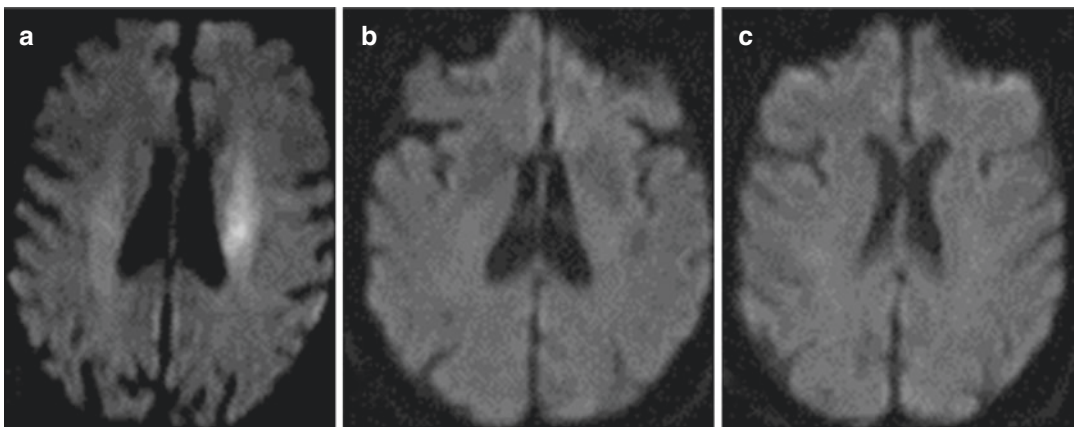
DWI Reversal. Serial diffusion-weighted imaging of acute left middle cerebral artery occlusion shows an initial subcortical abnormality (a) and complete
